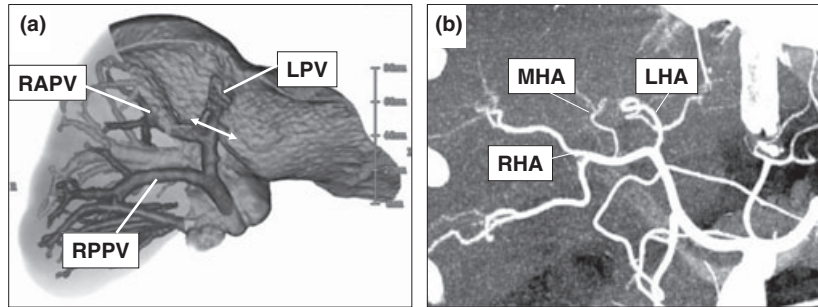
Preoperative three-dimensional CT imaging of the donor vessels. (a) The right anterior and posterior portal veins are independently derived from the main portal vein trunk. The portal vein of the graft is divided at a distal site to the right anterior portal vein takeoff (double arrow). (b) The hepatic artery to segment 4 (middle hepatic artery) is derived from the right hepatic artery. RAPV, right anterior portal vein; RPPV, right posterior portal vein; LPV, left portal vein; RHA, right hepatic artery; MHA, middle hepatic artery; LHA, left hepatic artery.
